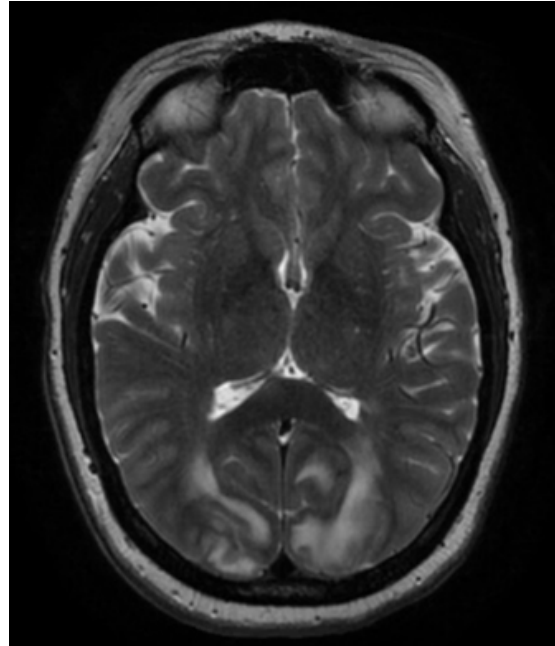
The MRI of the brain with axial T2 shows fairly symmetric subcortical area in a posterior predominant pattern including parietal lobes.
